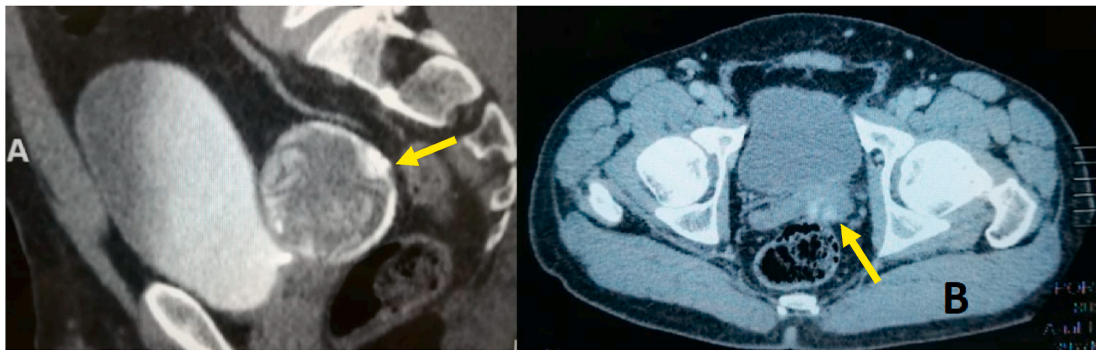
Sagittal computed tomography cut (A) and axial cut (B) showing a mass with serpiginous content, calcified in places developed from the left seminal vesicle (arrow).
